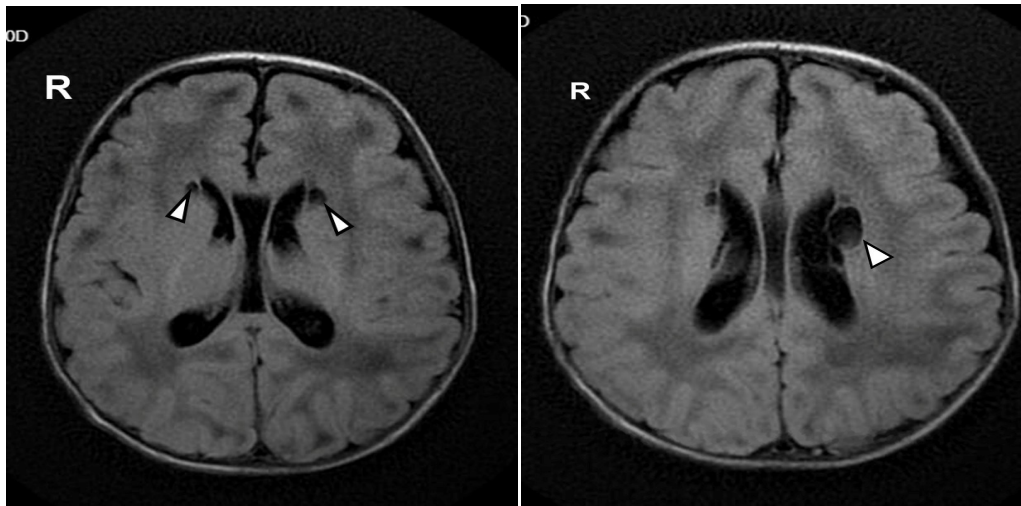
Cranial MRI T2 showed bilateral ventriculomegaly and encephaloma Lacia (arrows).
